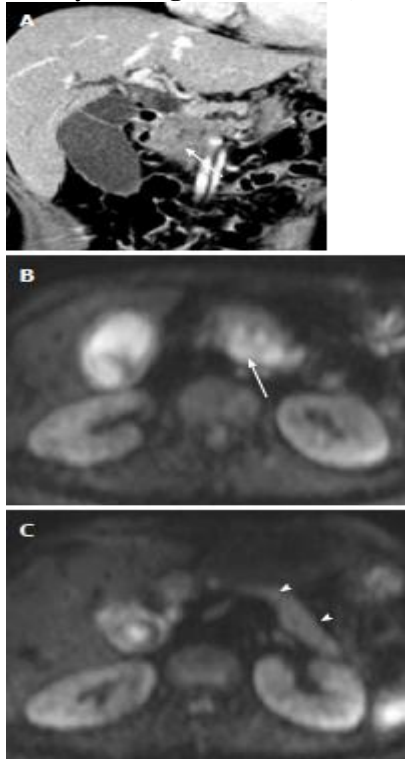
pancreatic adenocarcinoma in a 50-year-old woman. A: coronal reformatted contrast-enhanced CT image shows a double duct sign secondary to a pancreatic head cancer (arrow); B: On DWI at b = 800 s/mm², pancreatic adenocarcinoma (arrow) shows hyperintensity; C: DWI at b = 800 s/mm² superior to (B) shows high
